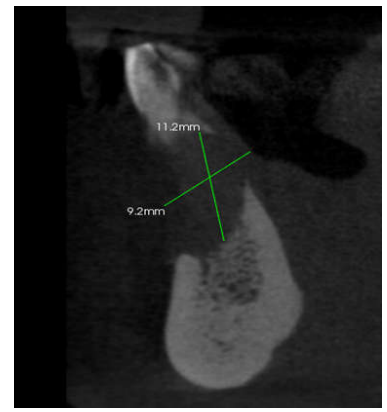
Saggital view cbct
